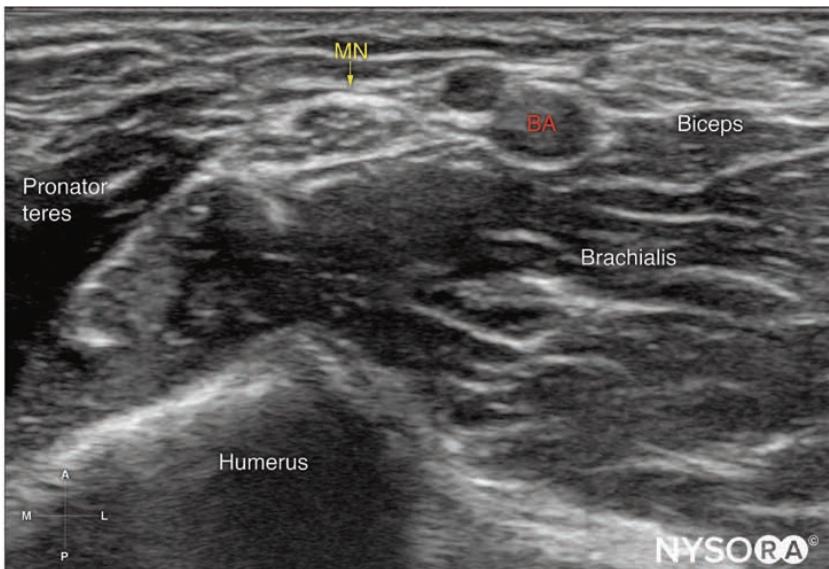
Probe position and ultrasound image of the median nerve (MN) above the elbow. BA, brachial artery.
